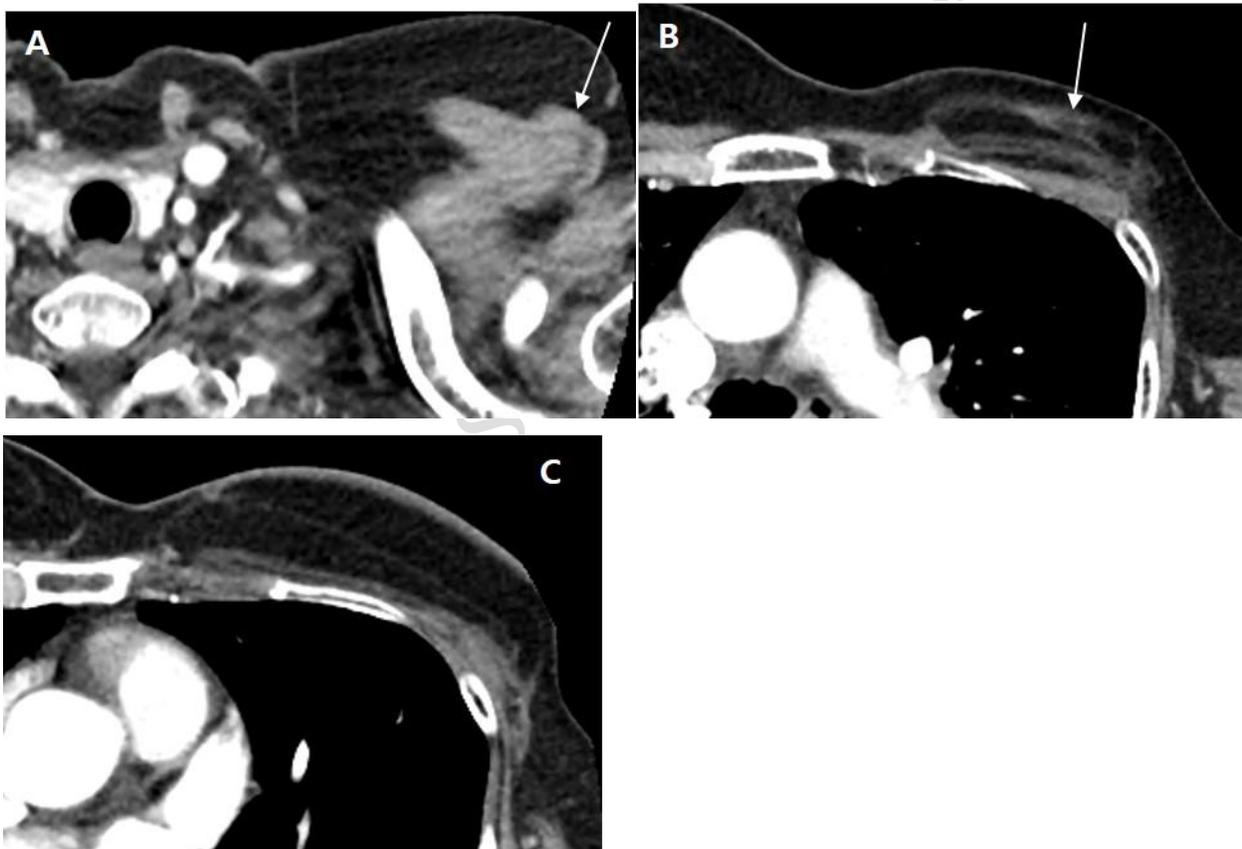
A: Chest CT showing the pedicle (arrow) originating from the upper left chest, extending anterior to the humerus, B: Sequential image showing the pedicle descending toward the thoracic wall, C: Chest CT showing the transferred latissimus dorsi flap forming fatty tissue within the left breast region, contributing to the maintenance of the reconstructed breast contour
